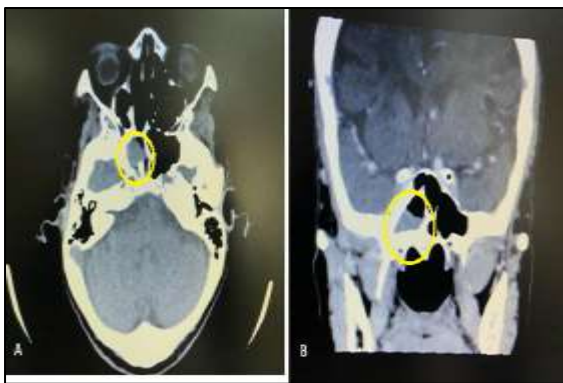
CT paranasal sinus, (A) Axial view, and (B) Coronal view, showed polypoidal mucosal thickening in the right sphenoid sinus (yellow circle).
